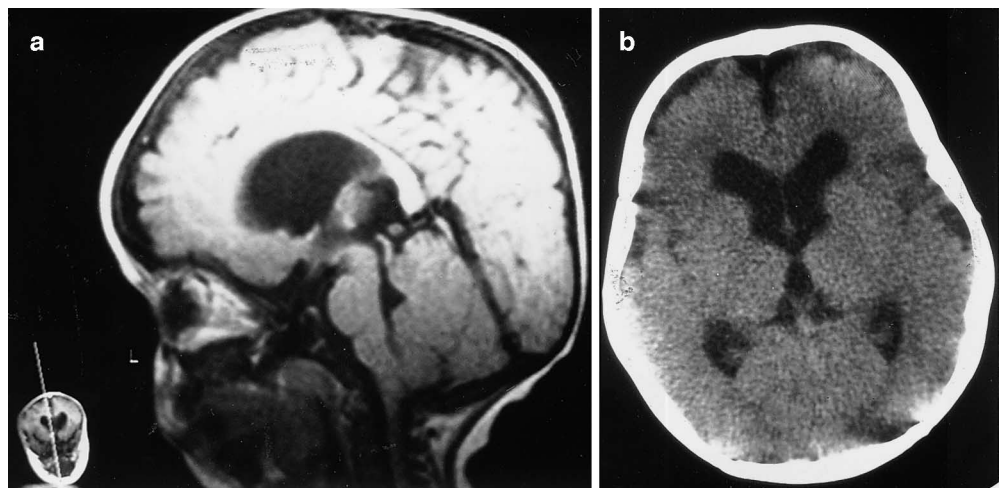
a Sagittal T1-weighted MRI scan shows abnormal vertical deviation of tentorium and enlarged vein of Galen. Elongation of brain stem, tectal beaking, decrease in ponto-mammillary distance, compression of IV ventricle and stenosis of foramen magnum were also seen. b Preoperative CT scan shows moderate ventriculomegaly
